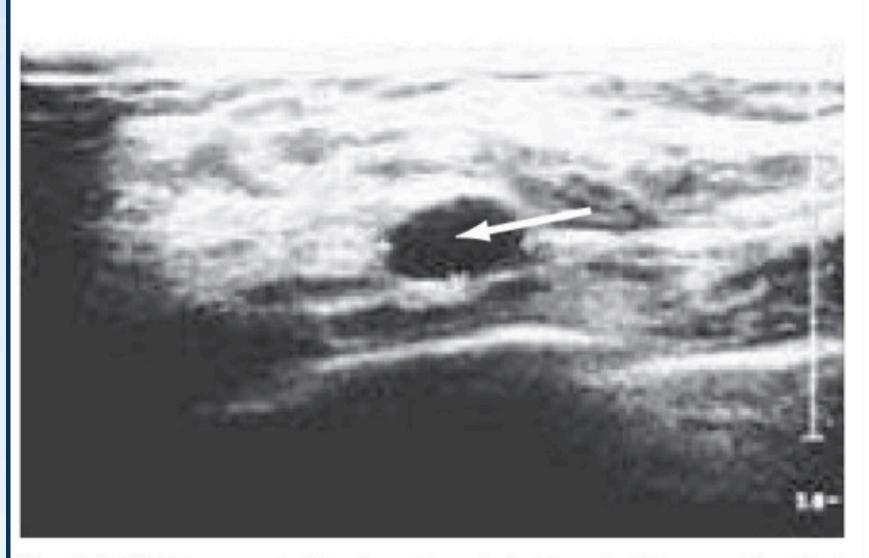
Ultrasound of a breast cyst. A characteristic smooth-walled, hypoechoic lesion (arrow).
